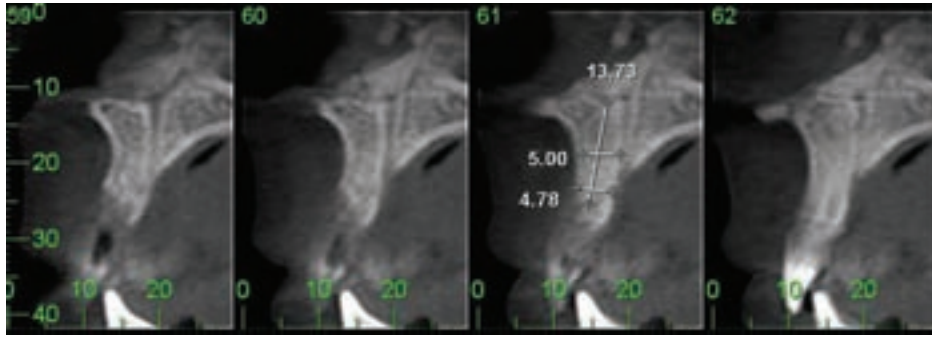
Reformatted cone beam computed tomographic views of the site of a missing upper right central incisor site (slices 59 and 60) adjacent to the upper left central incisor (slices 61 and 62). By observing the “ghost image” of the left incisor over the right incisor ridge, it is possible to determine that there is sufficient bone volume to place an implant in the correct axial position. However, a fenestration of the facial bone could occur at the time of surgery.
